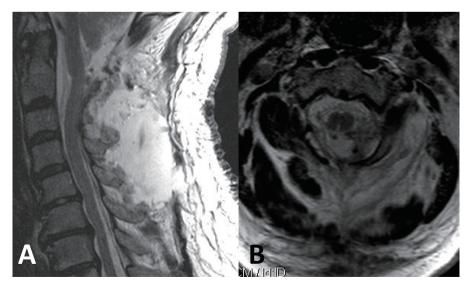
Postoperative MRI (sagittal; A, axial; B) obtained three days after the surgery shows that the dermal sinus is completely resected, and displacement of spinal cord is corrected successfully (A). Syrinx is also shrinking (B).
